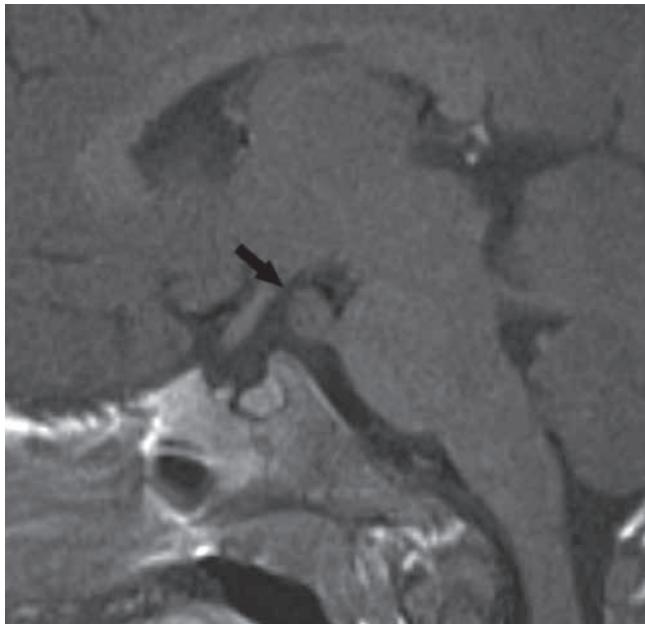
Sagittal T1 post-gadolinium MR image demonstrating the location of the lesion adjacent to the pons (arrows). There was no contrast enhancement of the lesion.
